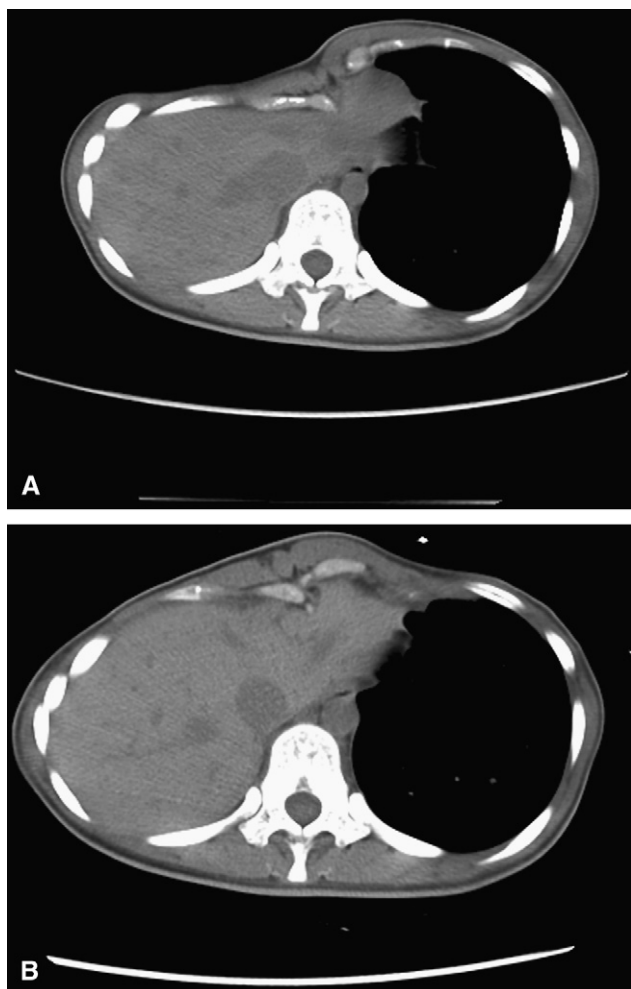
A, Preoperative lower chest computed tomographic scan. B, postoperative chest computed tomographic shows improvement of the deformity.
